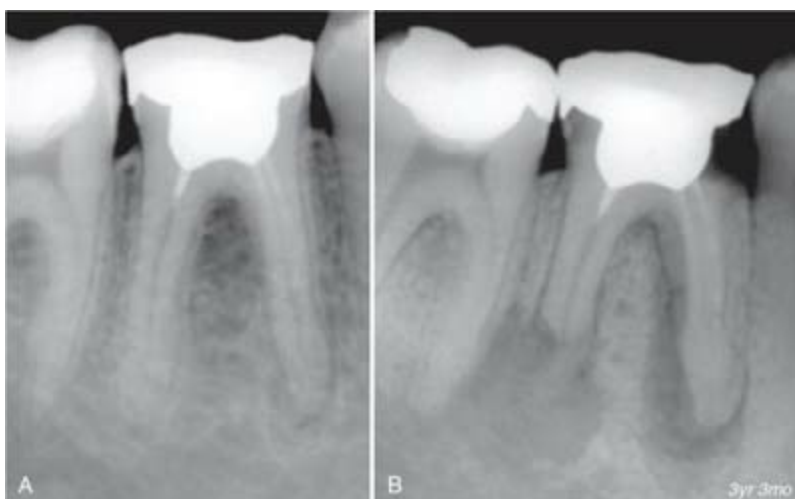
Apical resorption. A, 22-year-old male patient complained of pain on chewing. This was caused by a molar that had been treated endodontically 1 year earlier. A radiograph showed obturation material only at the root canal orifices and a periapical radiolucency on the mesial root. Endodontic retreatment was recommended, but the patient declined this treatment. B, The patient returned 3 years and 3 months later because of an abscess that was causing severe pain. A radiograph disclosed destructive mesial caries and large periapical radiolucencies on both roots, along with resorption of the whole apical third of the distal root.
